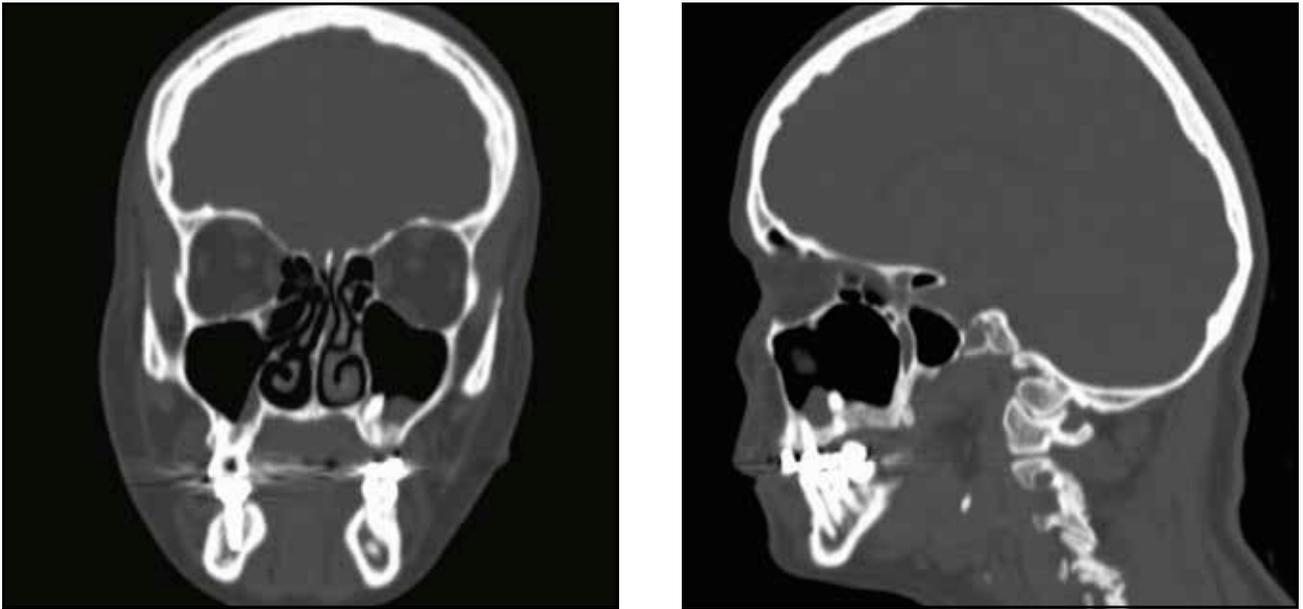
Cranio-facial CT scan, coronal and sagittal sections - a tooth in the left maxillary sinus.
